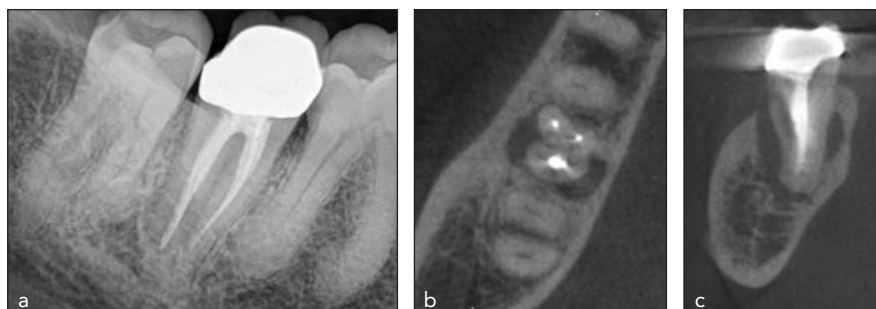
Failure due to vertical fracture in the distal root of the mandibular right second molar. The vertical fracture and resultant bone loss is less apparent in the periapical radiograph (a) than in either the axial (b) or coronal (c) CBCT images.
